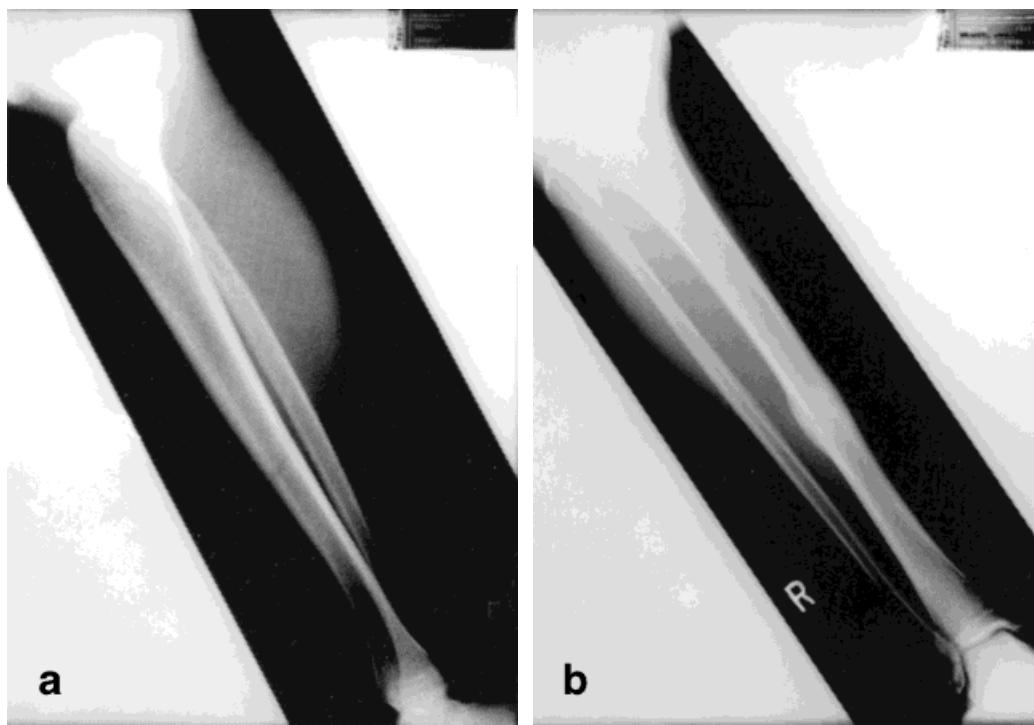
Transverse fracture due to direct trauma. a: Radiograph taken immediately postinjury, showing a transverse midshaft fracture without fibular involvement. b: Radiograph taken more than 5 months later, showing callus around the fracture site.
